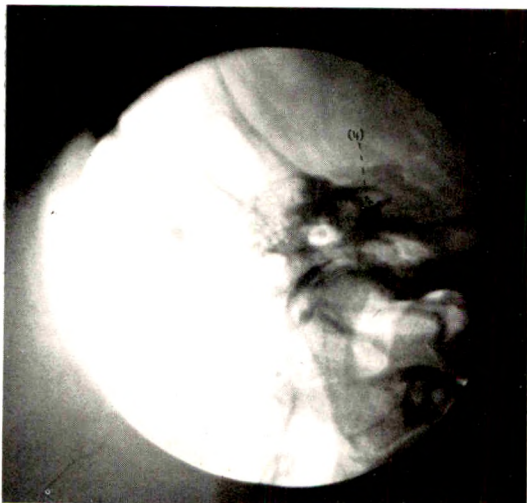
Roentgenogram of the petrous pyramid in the Stenvers position. Less exposure is necessary in order to bring out the cortical and tip cells of the mastoid process.
